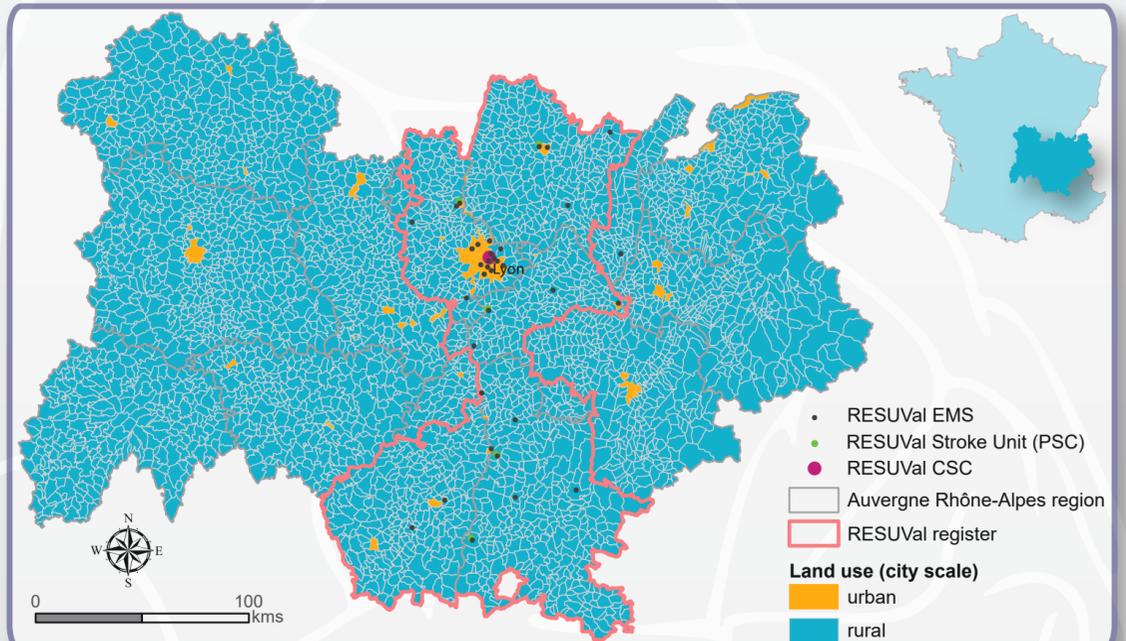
RESUVal area, hospitals repartition and land use
